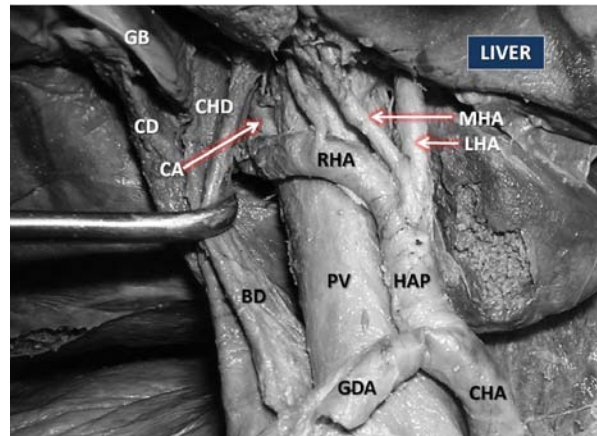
Dissection of the coeliac trunk (CT) and its branches showing the normal origin of hepatic artery proper (HAP) and gastroduodenal artery (GDA) from common hepatic artery (CHA). HAP trifurcating to give middle (MHA), Left (LHA) and Right hepatic artery (RHA). RHA on its further course turning right deep to common hepatic duct (CHD) and giving branch to liver (\*). SA- splenic artery, LGA- left gastric artery, PV- portal vein, BD- bile duct, CD- cystic duct, GB- gall bladder
